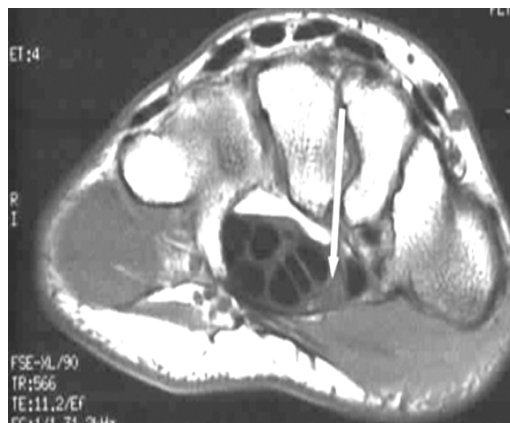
Normal findings on an axial spin-echo T1 WIs. MRI of the carpal tunnel is showing the intermediate signal intensity of the median nerve (arrow) (Allmann et al., 1997).*
